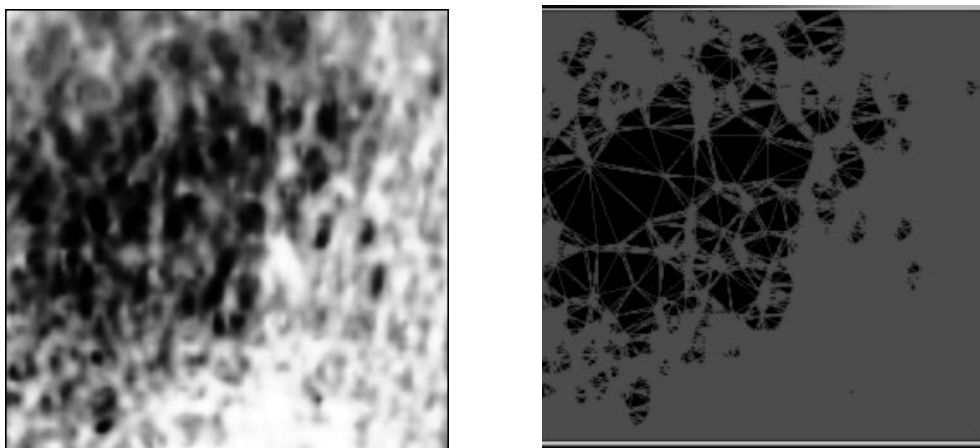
Radiographic image of the region under analysis (a), automatic mesh generation (triangular cells) (b)
